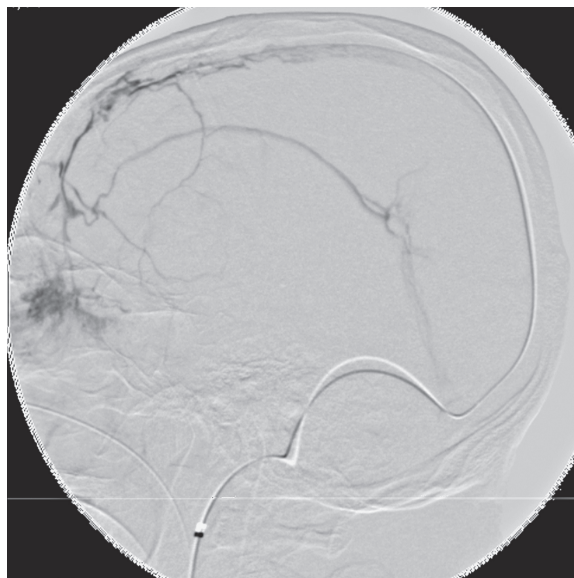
Cerebral venogram. Lateral view with injection through a micro catheter showing near complete occlusion of the superior sagittal sinus and diverted venous flow anteriorly through the inferior sagittal sinus, prior to ultrasound therapy..
